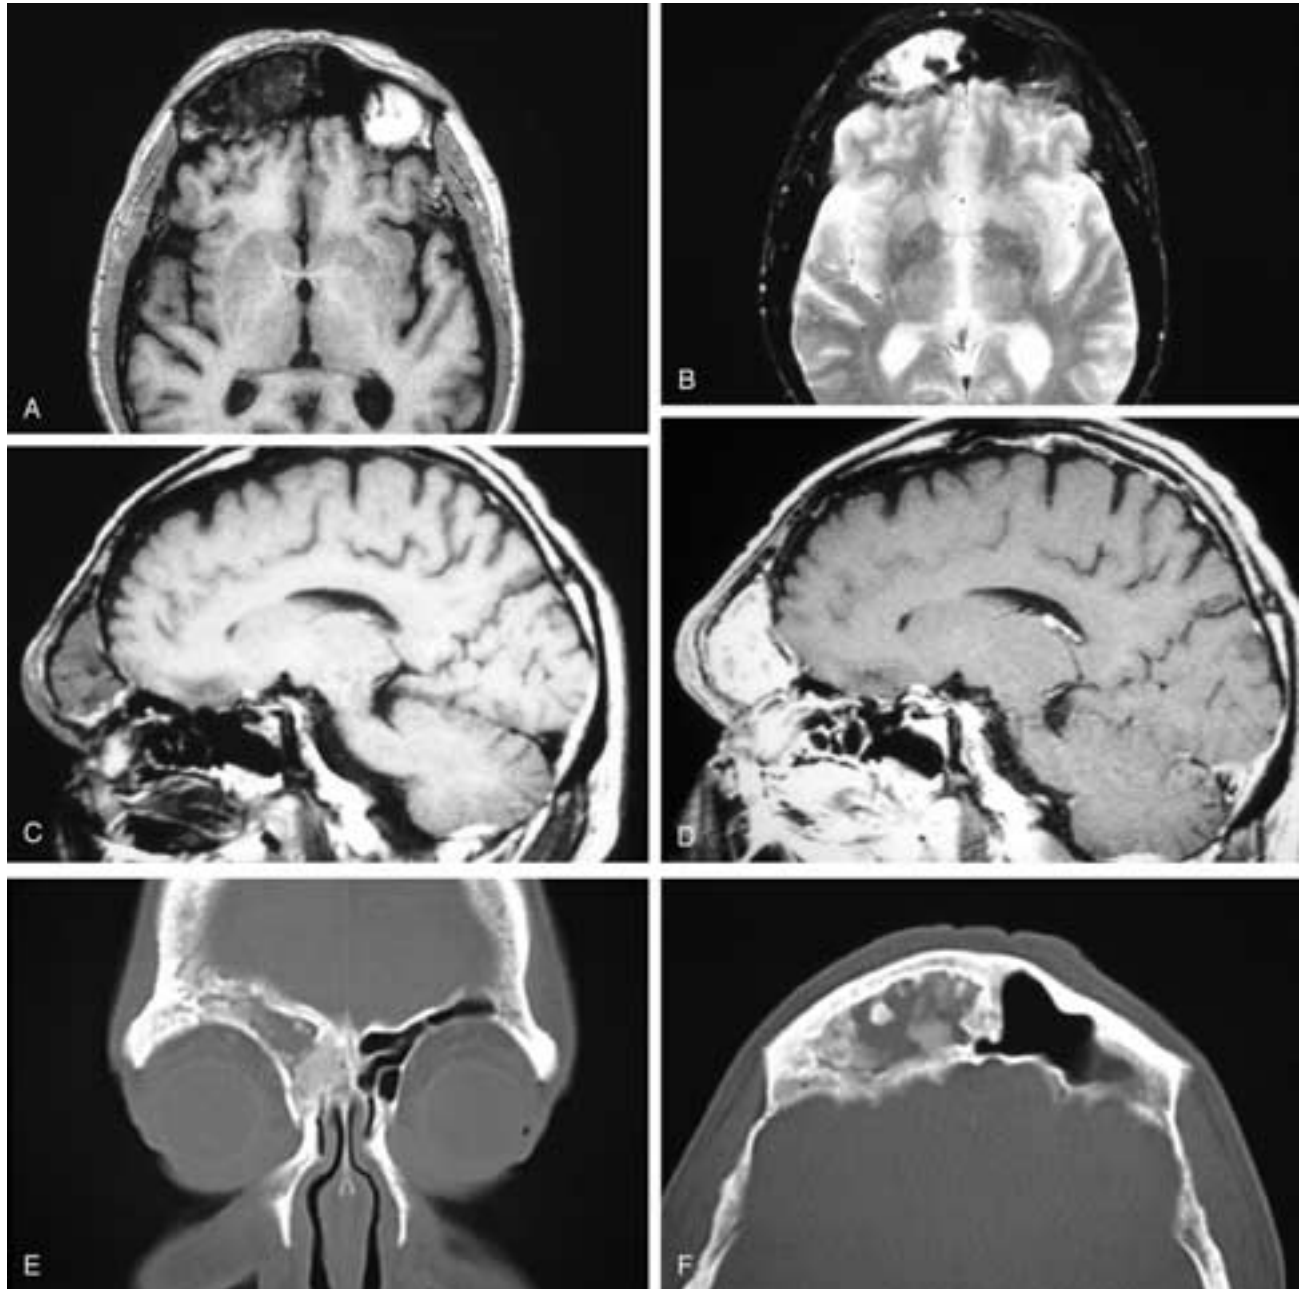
Axial T1-weighted (A), T2-weighted (B), sagittal T1-weighted (C), and T1-weighted, contrast-enhanced (D) MR images and coronal (E) and axial (F) CT scans show a nonhomogeneous right frontal sinus mass that has low signal intensity in A, high signal intensity in B, and diffusely enhances in D. The CT scans show the bone to be expanded, with intact cortices and a medullary space filled with ossified and nonossified regions. This patient had fibrous dysplasia.
